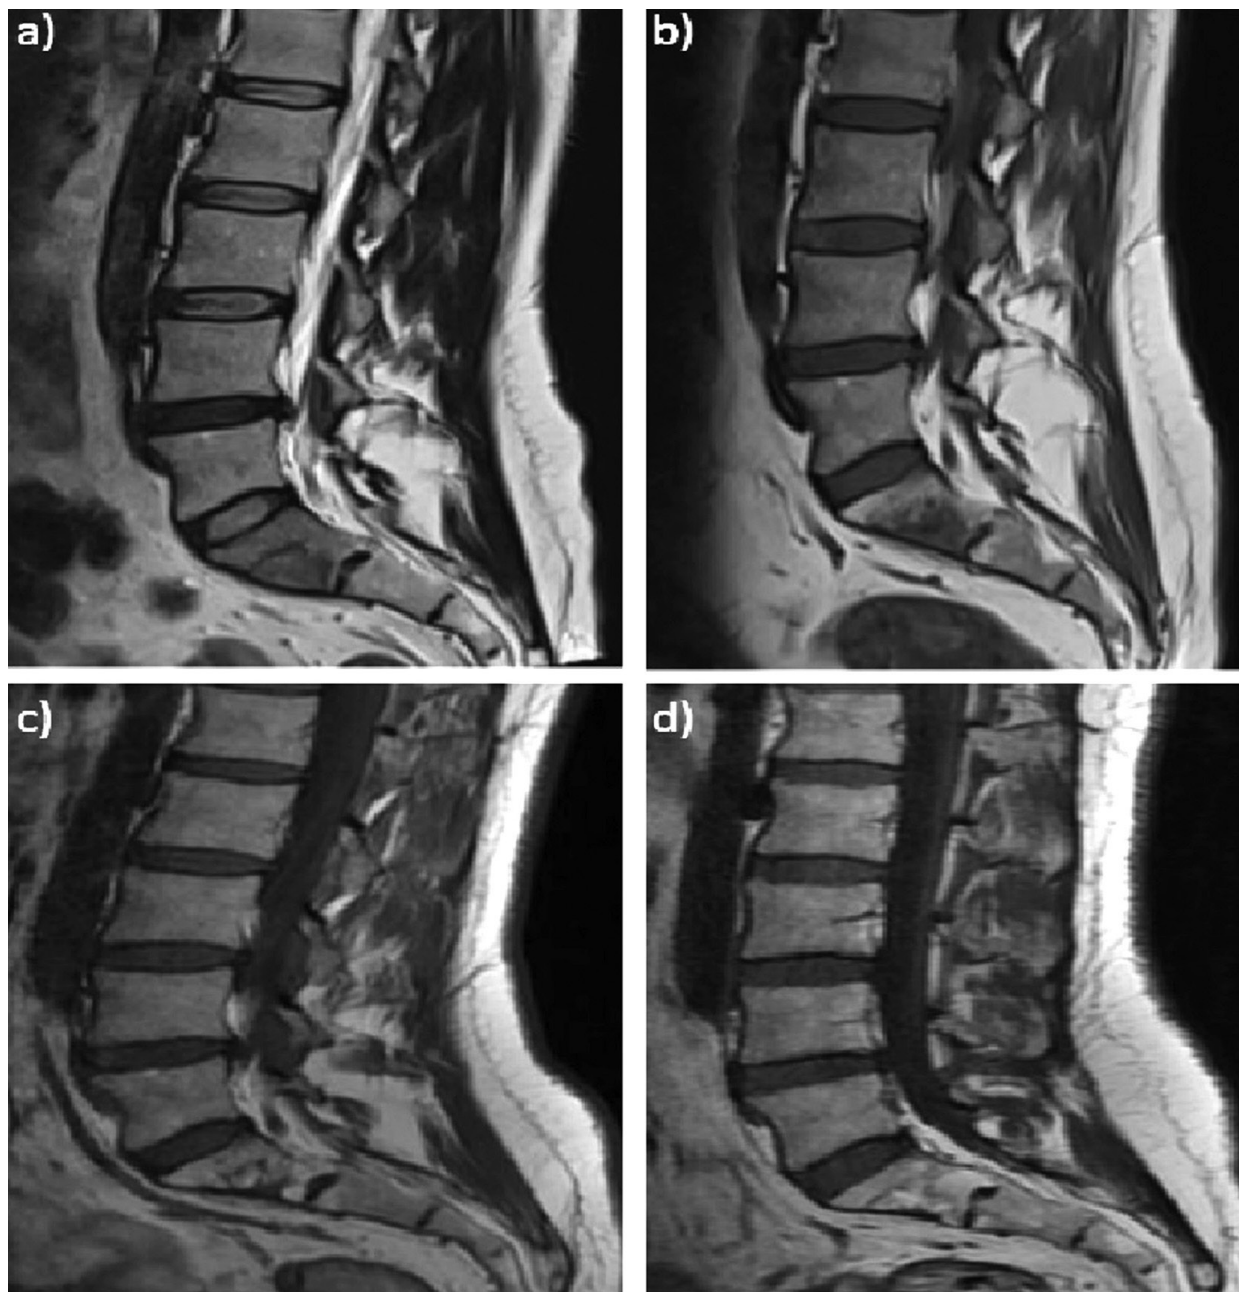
Radiological imaging of a 47-year-old male patient with S1 vertebral bone involvement a) MRI was taken after the patient had low back pain, hypointense signal was present in the S1 vertebra in the sagittal T1 sequence. b, c, d) Sagittal T1 sequence of the patient's control MRI was taken six months, one year, and two years later.
